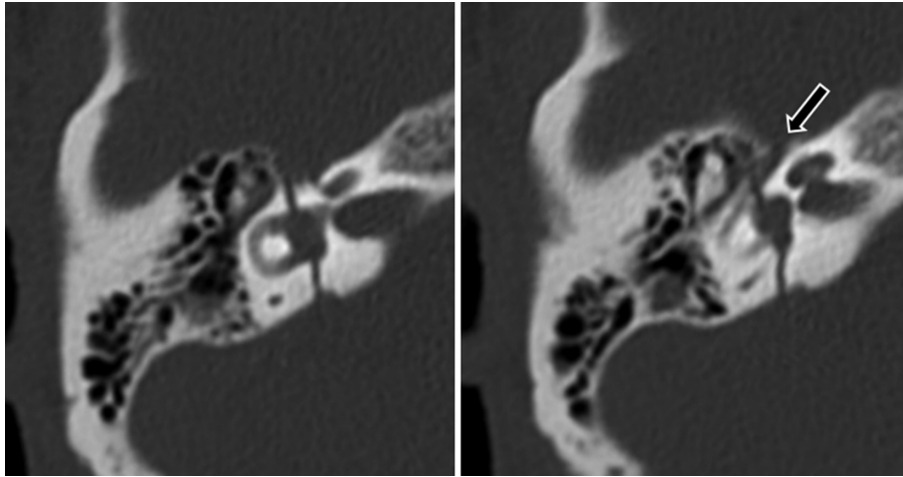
Axial computed tomography image of the right temporal bone demonstrates the fracture through the vestibule and the facial nerve canal (arrow); the cochlea was spared.
